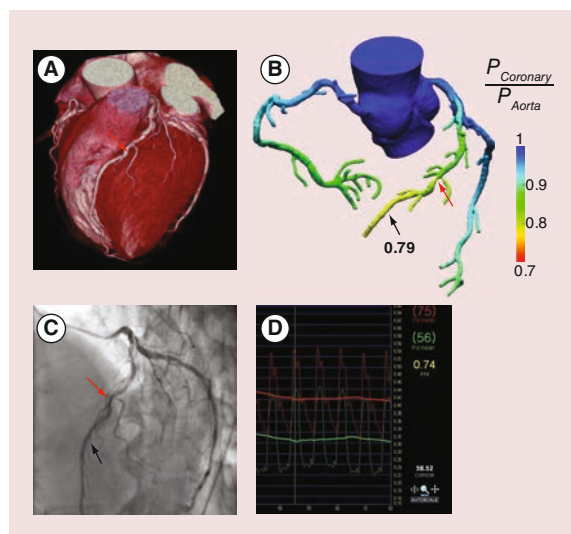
A representative case of computed tomography-derived fractional flow reserve. (A) Conventional cCTA detects a focal luminal narrowing (red arrow) in the distal LAD. (B) The FFR_{CT} demonstrates that the aforementioned focal stenosis (red arrow) is responsible for ischemia, with a computed value of 0.76 (black arrow). (C) Invasive coronary angiography confirms the stenotic segment in LAD (red arrow), and invasive FFR is measured at the corresponding point where FFR_{CT} is calculated (black arrow). (D) The value of invasive FFR is 0.74, which is similar to that of FFR_{CT} .
